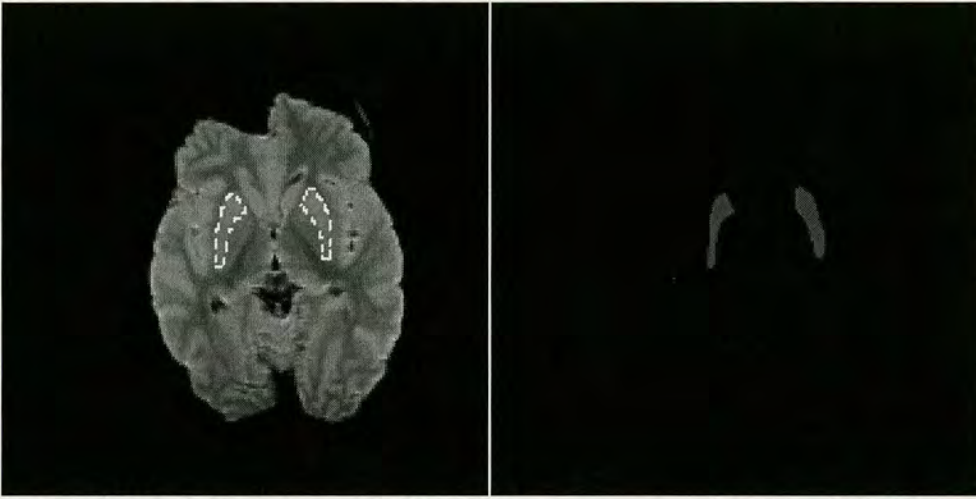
Segmentation: A typical PD weighted MRI (left) and a simple mask image (right) indicating the Putamen region of the brain.*
